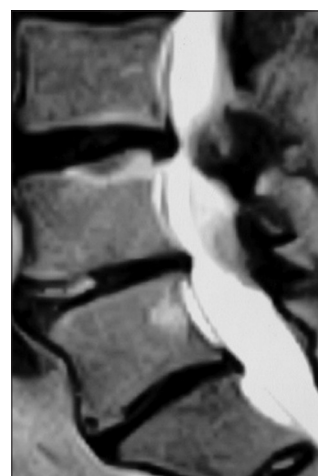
On the T2-weighted parasagittal MR scan, a massive L4–L5 heterogeneous synovial cyst (isointense capsule, hypointense cyst) contributes to marked thecal sac compression extending all the way to the L3–L4 level
